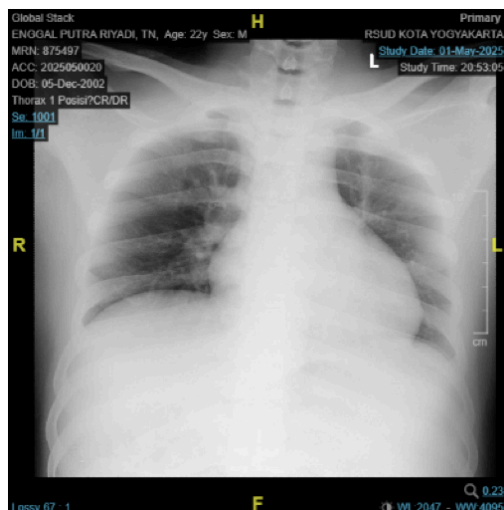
Thoracic x-ray, within normal limits.
